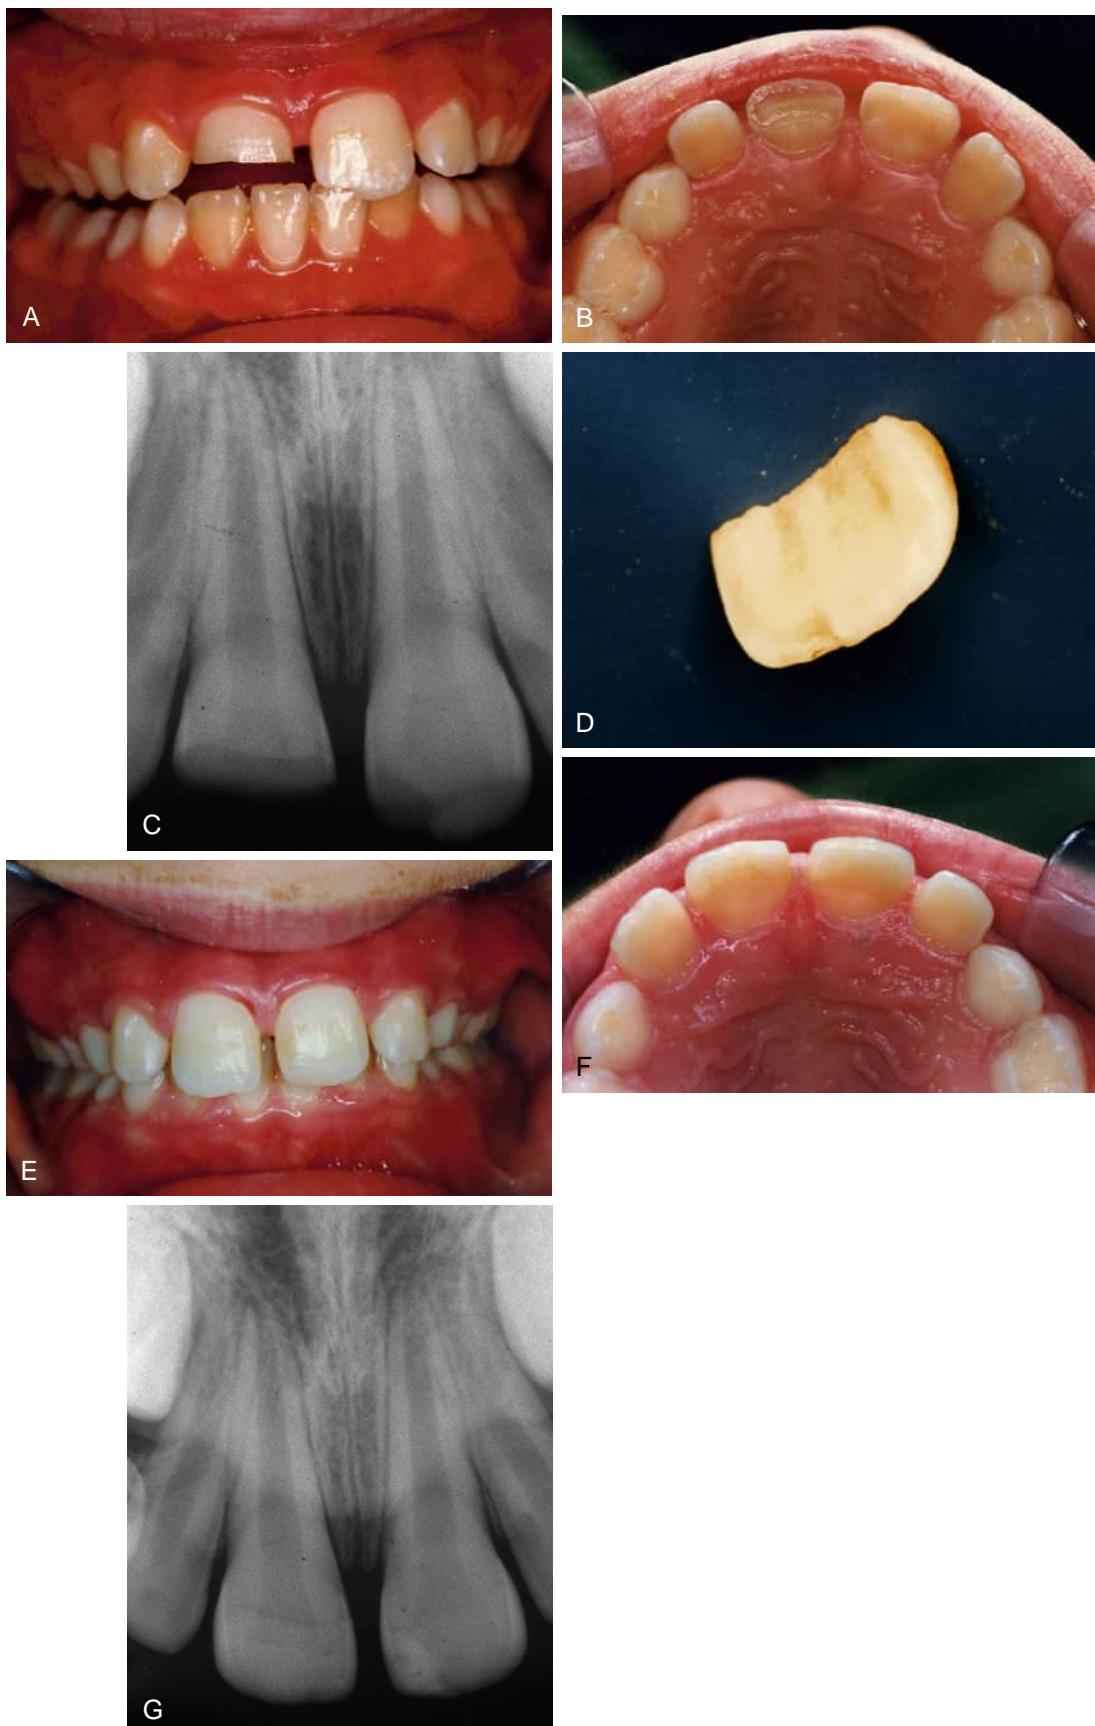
(A) Significant uncomplicated fracture (not involving the dental pulp) of a maxillary right central incisor. (B) The exposed dentin was closely examined to ensure that no exposure of the pulp was present. Next, all exposed dentin was covered with hard-setting calcium hydroxide; all fractured enamel remained exposed. (C) Radiograph of fractured incisor demonstrating stage of root-end development and the absence of root fracture. (D) Fractured part of central incisor. Part of the dentin was removed from the tooth fragment; the enamel was not disturbed. (E) Facial review of restored tooth 12 months after injury. (F) Incisal view of the restored tooth 12 months after injury. (G) Radiograph of the restored tooth 12 months after injury.
